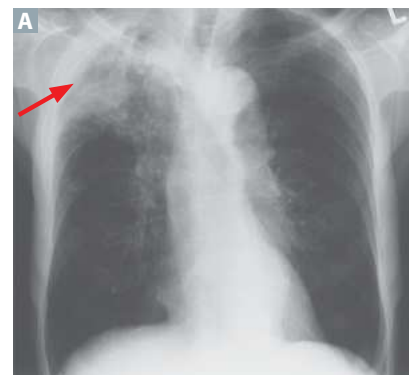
Pulmonary TB. (A) Right apical opacity with areas of cavitation (arrow) is seen in an older adult patient with reactivation TB. (B) Cone-beam CT scan in a young man with miliary TB shows innumerable 1- to 2-mm pulmonary nodules. (Image A reproduced with permission from Halter JB et al. *Hazzard's Geriatric Medicine and Gerontology*, 6th ed. New York, NY: McGraw-Hill; 2009. Image B reproduced with permission from USMLE-Rx.com.)
